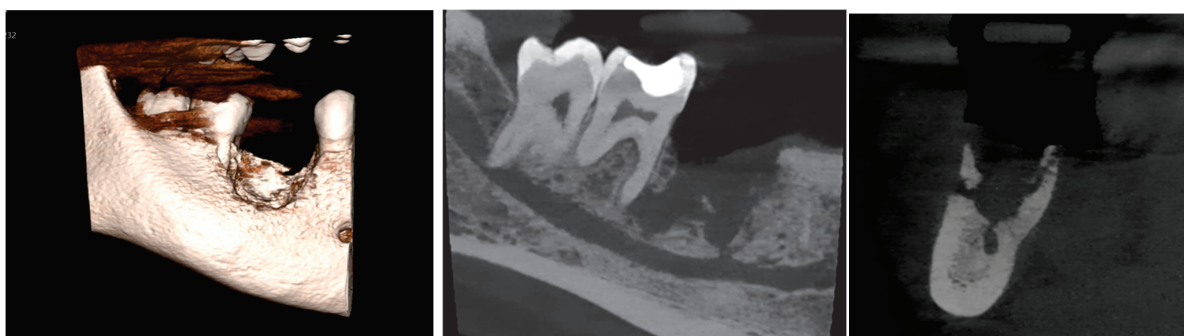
A postoperative CBCT of the LR6 during the follow-up visit.
